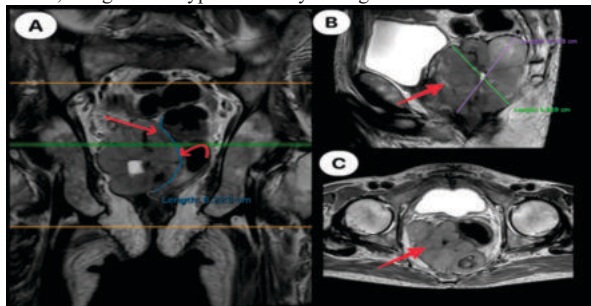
reveals coronal (A), sagittal (B) and axial (C) planes of T2 weighted MRI images showing a well-defined lobulated lesion with external capsule (red arrow). The curved arrow shows the margin of rectal wall involved.
